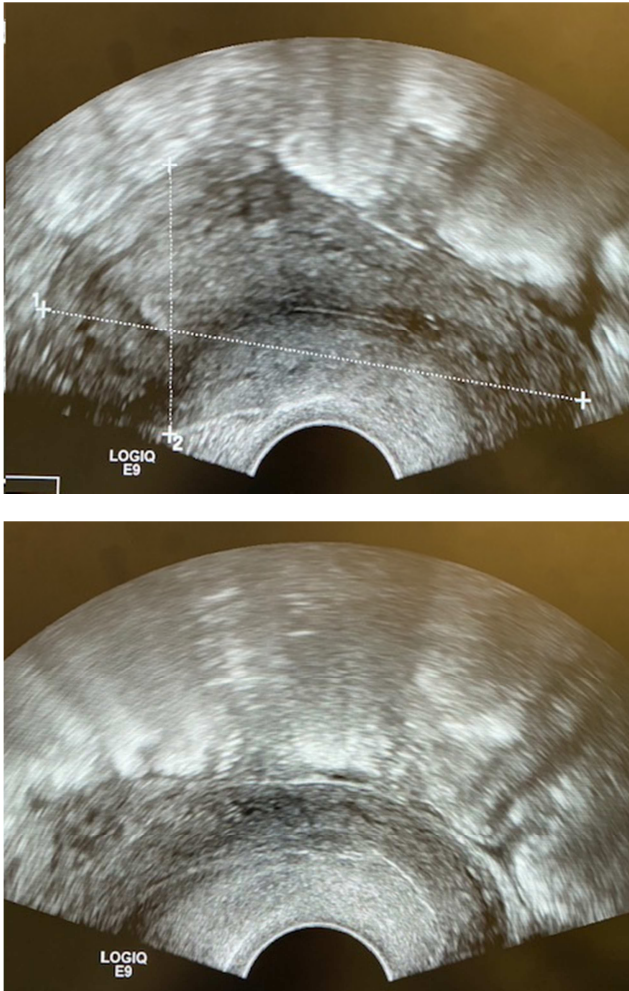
Images of CEP one month post methotrexate by pelvic ultrasound (vaginal approach).
